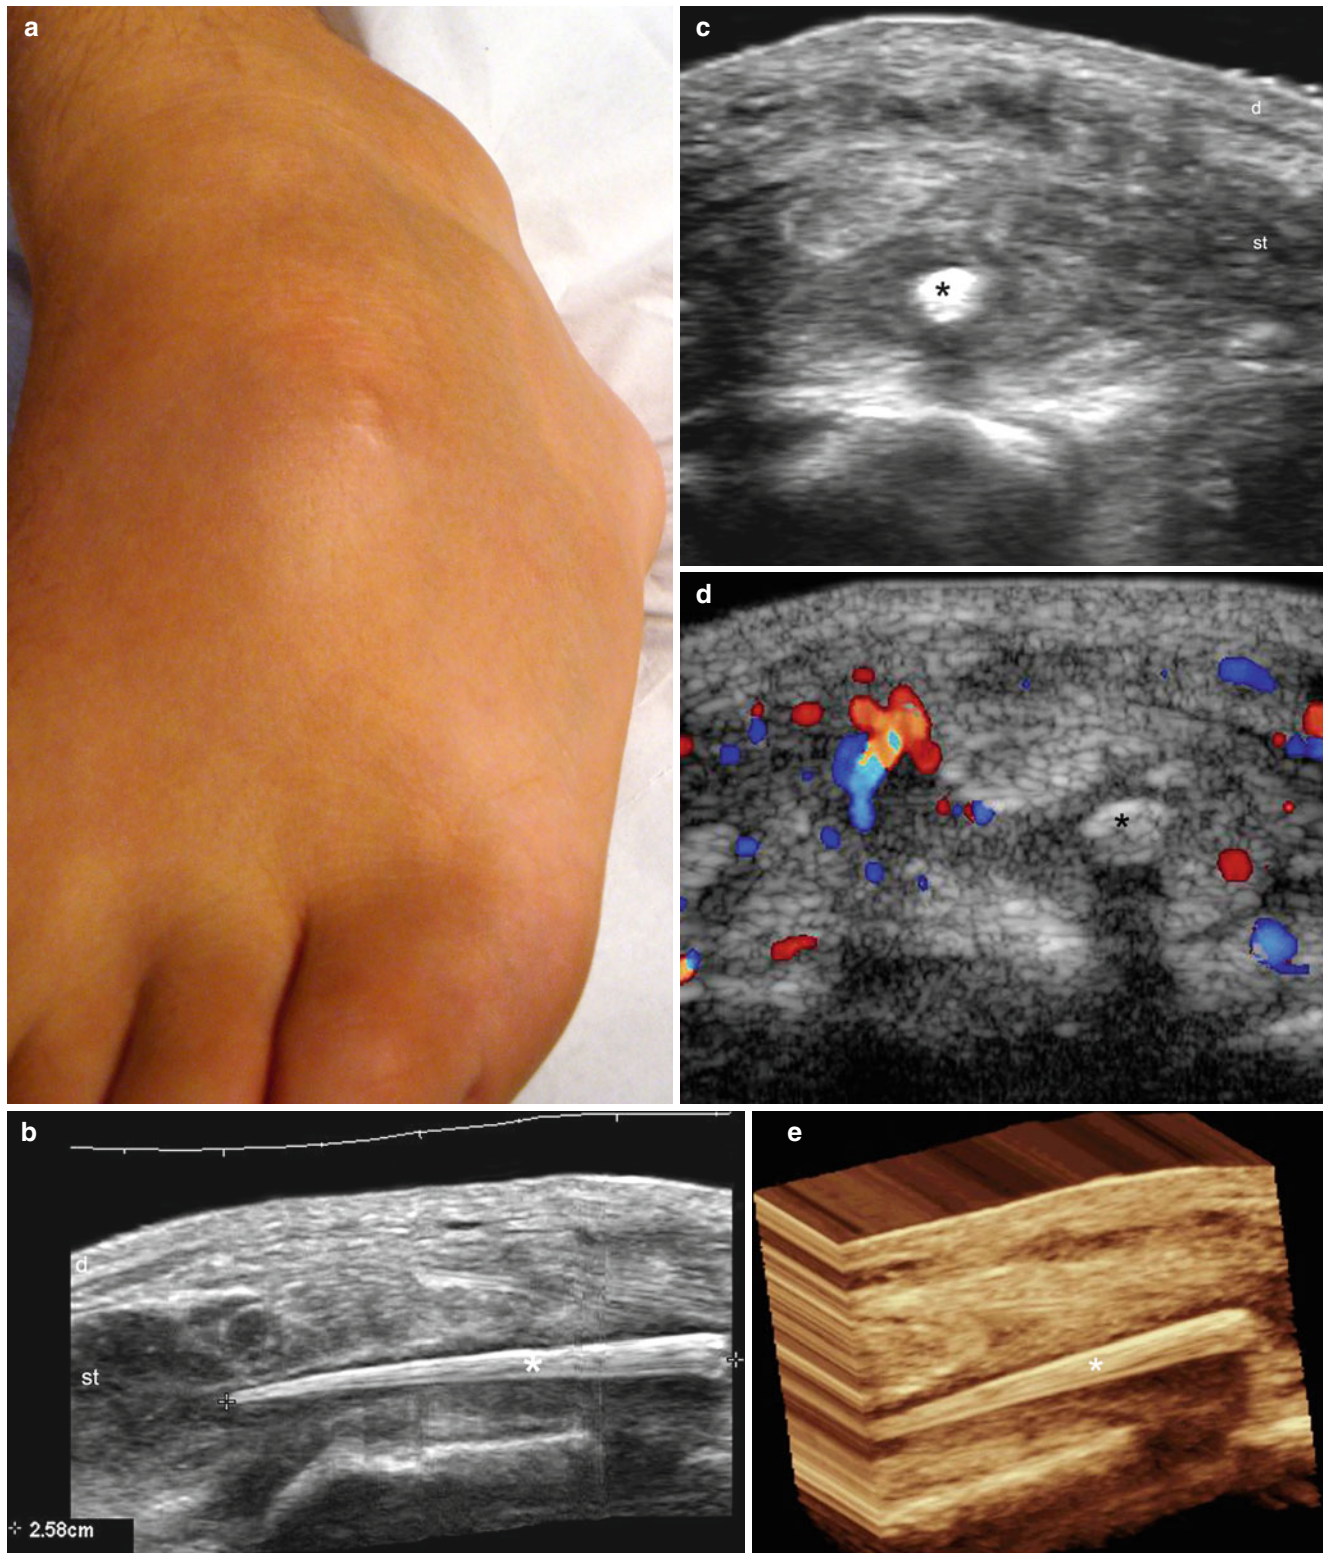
(a–e) Organic foreign body. (a) Clinical image shows a swelling in the anterolateral aspect of the left foot. (b) Gray scale ultrasound image (longitudinal view) demonstrates a 2.58 cm, well defined, hyperechoic band (*) with tapering of its distal part, located in the subcutaneous tissue that corresponded to a fragment of a leaf of a palm tree. (c) Gray scale ultrasound image (transverse view) demonstrates
